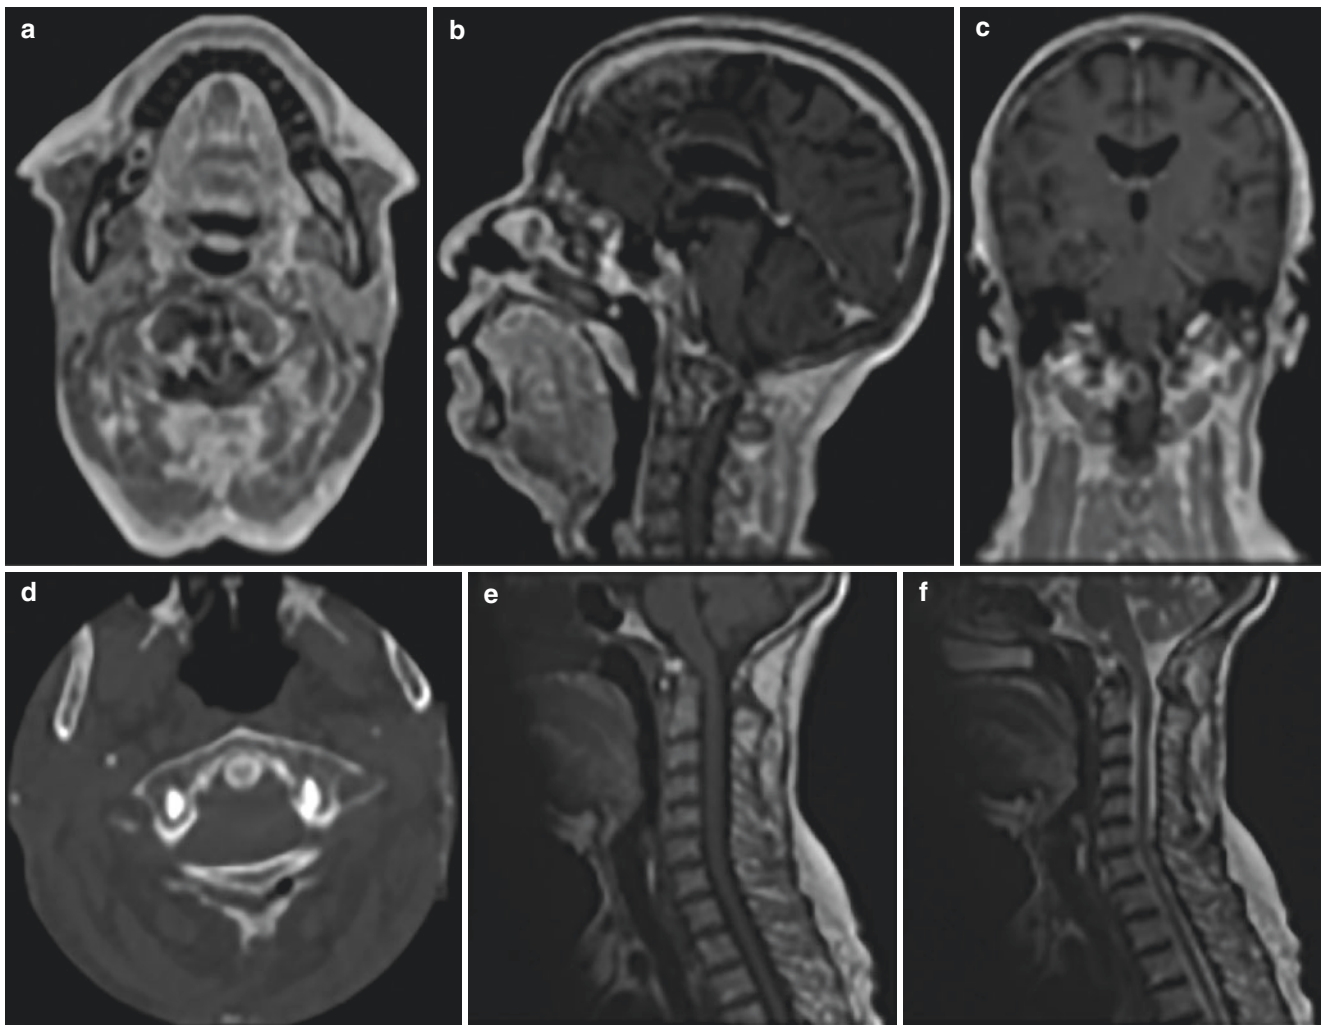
Post-contrast T1 axial (a), sagittal (b), and coronal (c) MRI images showing a retro-odontoid degenerative pseudotumor (retro-odontoid pannus) causing spinal cord compression; (d) postoperative
